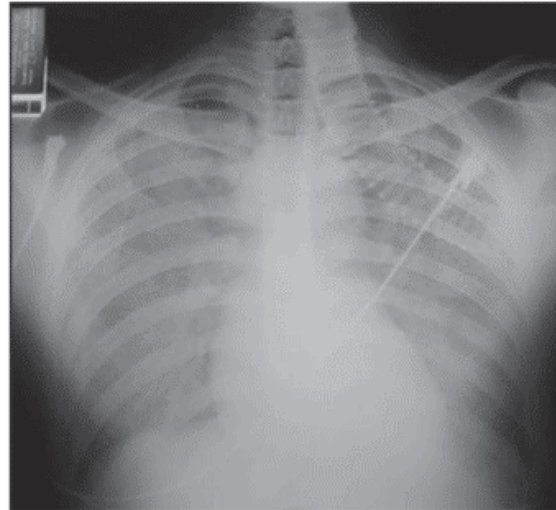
Chest radiograph 1 day after admission to the intensive care unit
